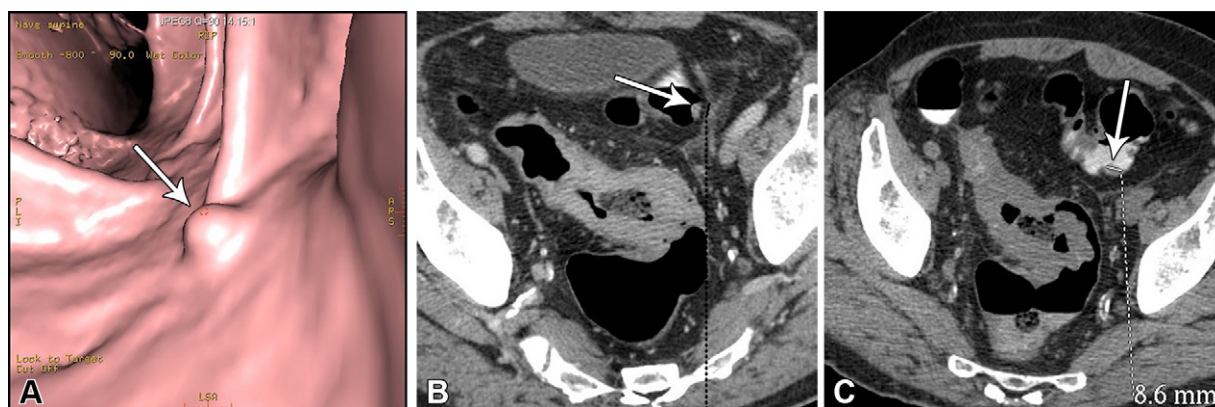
Sessile polyp. A 77-year-old male patient presented for CT colonography following an incomplete colonoscopy for an obstructing sigmoid colonic mass. An 8-mm sessile polyp (arrow) is identified in the proximal sigmoid colon on the (A) three-dimensional endoluminal view, (B) axial prone view, and (C) axial supine view. Note that the polyp has a broad base without a neck or stalk. A tubular adenoma was diagnosed at colectomy.
